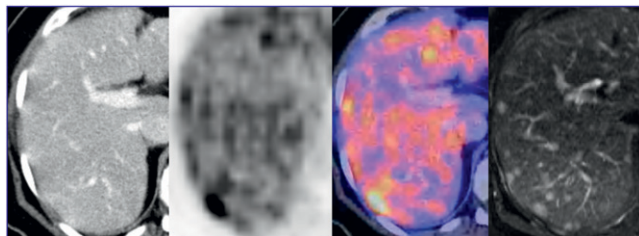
Comparative detection of liver metastases. Images acquired in a 62-y-old patient with ileal carcinoid and hepatic metastases. Left to right: CT, PET, PET/CT, and MR transverse images.
